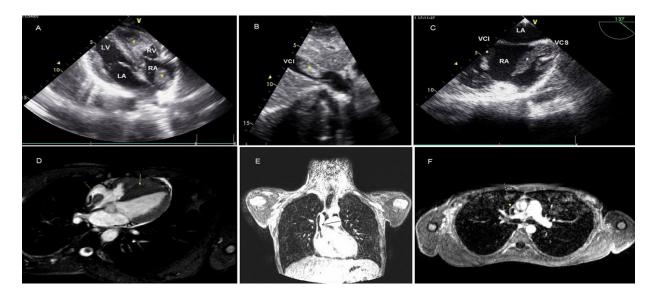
Transthoracic echocardiography shows mobile thrombus images in RA and RV in apical 4chamber view (1-A), and in the IVC in subcostal view (1-B) (asterisk), and also mobile thrombi seen from IVC and SVC extending into the RA in bicaval view on transesophageal echocardiography (1-C) (arrows). MRI reveals mobile thrombus images in the SVC (1-E,1-F) and in the base of RA and plastered thrombus on RV walls, filling almost one half of the RV cavity(1-D) (arrows).
